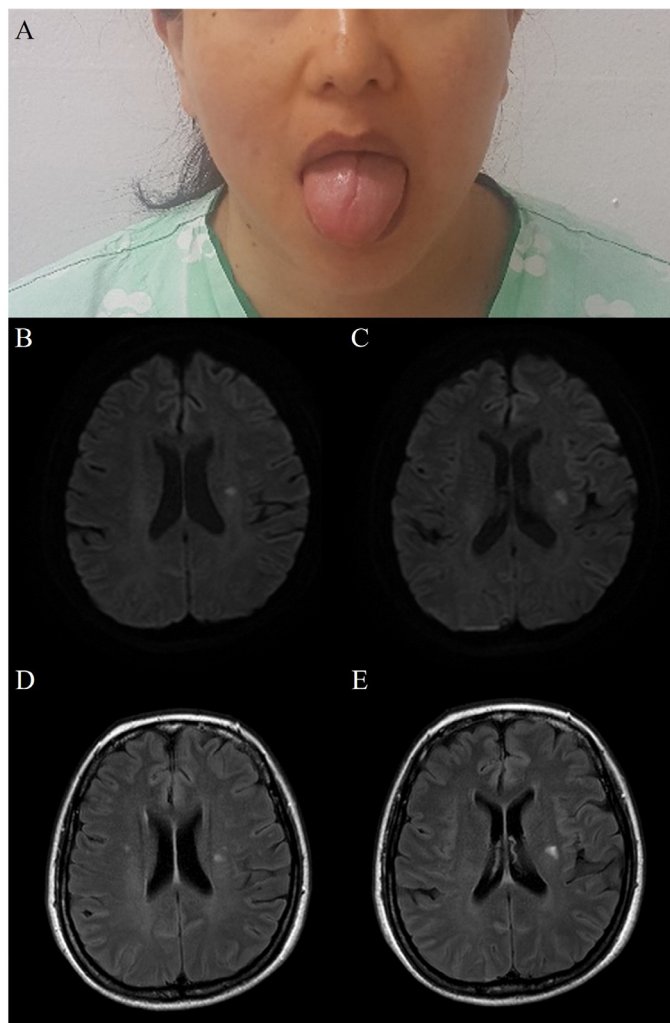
(A) Tongue deviated to the right on protrusion. (B-E) Brain magnetic resonance image high signal changes in the left corona radiate and basal ganglia on diffusion-weighted images (B-C) and T2 fluid-attenuated inversion recovery (D-E).
